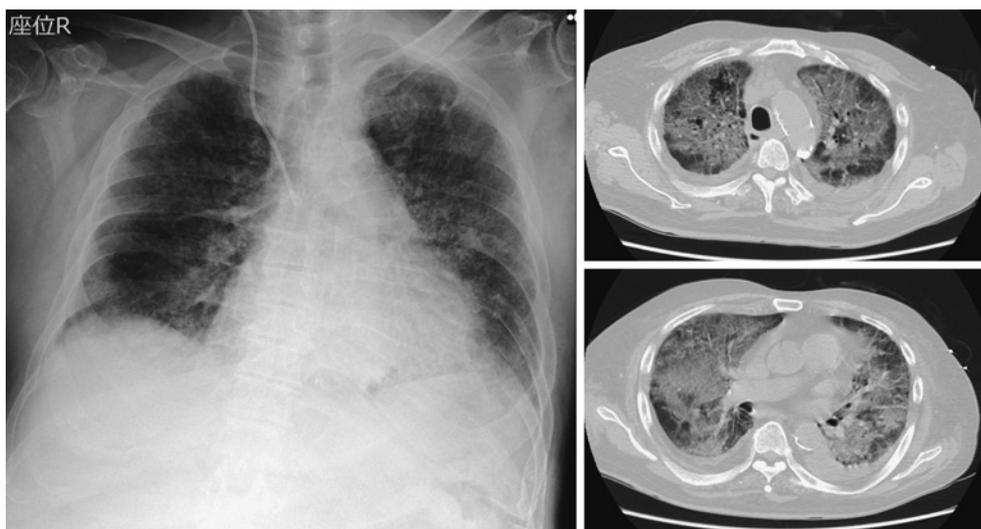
Supine chest X-ray (CXR, left) and computed tomography (CT, right) taken on re-admission to the intensive care unit. CXR shows diffuse ground-glass opacity, blunted border of diaphragm, and cardiomegaly. CT also shows diffuse ground-glass opacity, indicating recurrence of pneumonia and pulmonary edema.
